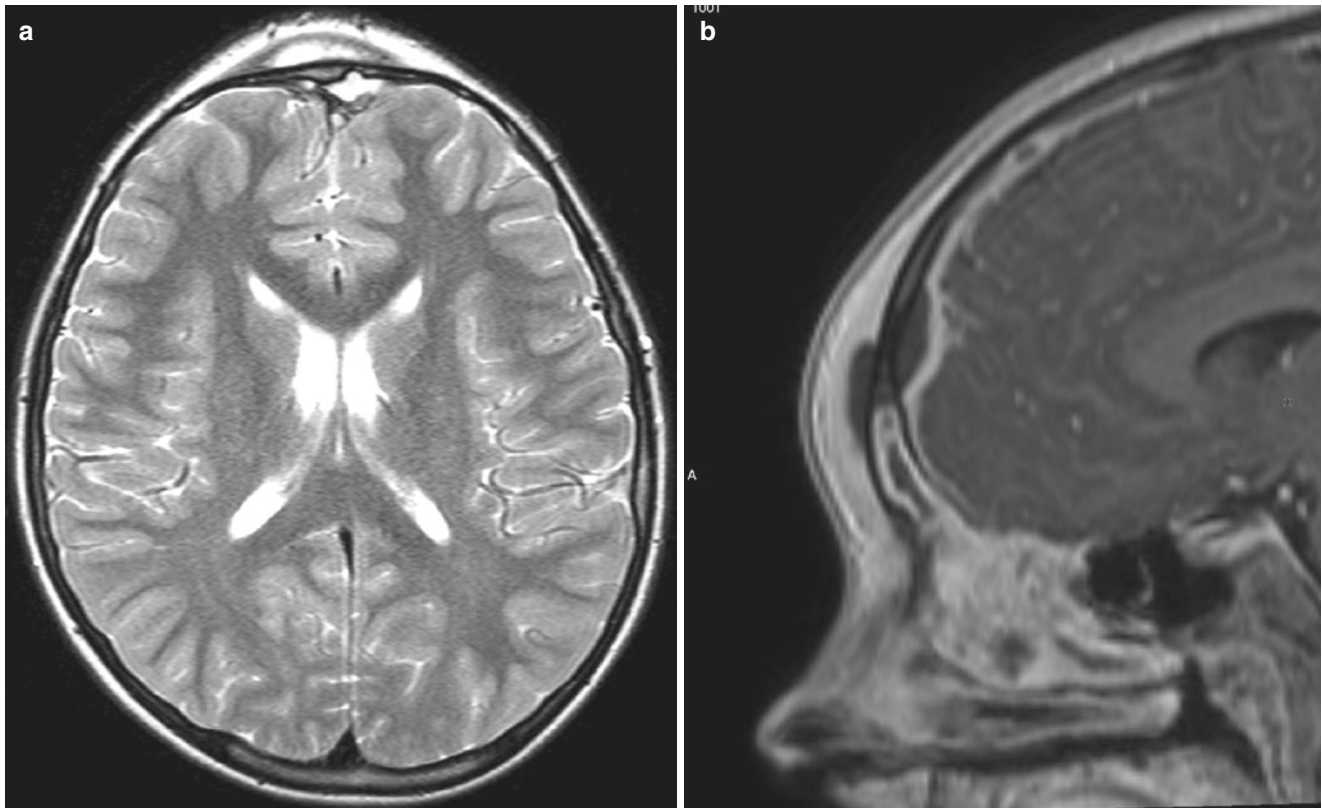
Epidural abscess and subperiosteal collection secondary to frontal sinusitis and osteomyelitis. (a) Axial T2-weighted MR image shows a small, hyperintense left frontal epidural collection and a hyperintense subperiosteal collection. (b) Sagittal post-contrast T1-weighted
